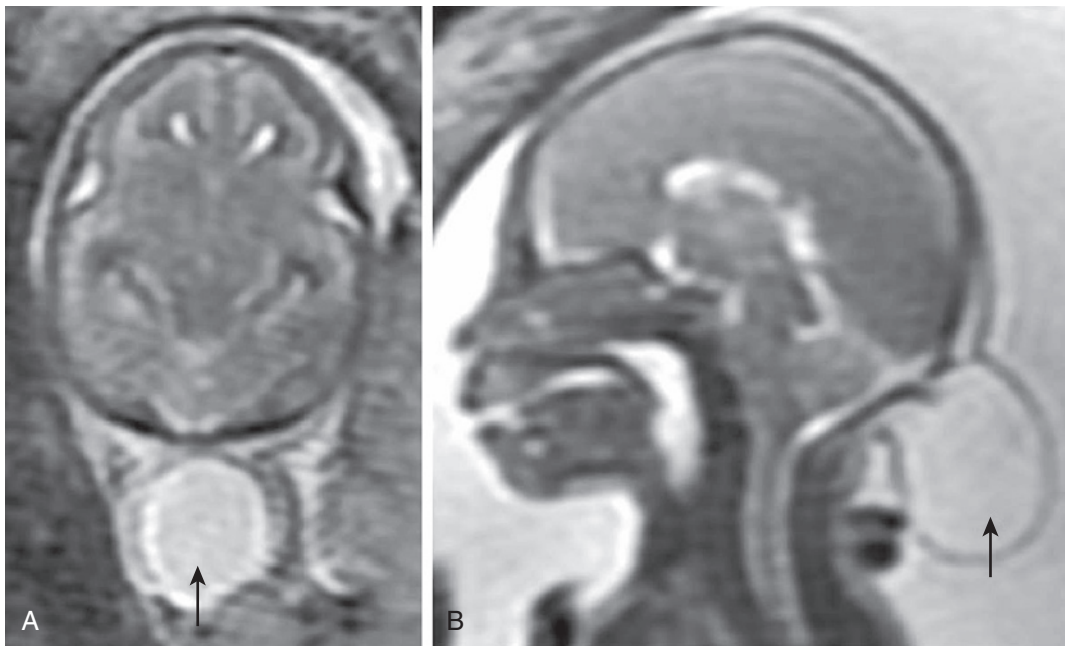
Fetal magnetic resonance imaging (MRI) showing occipital meningocele. T2-weighted fetal MRI axial (A) and sagittal (B) views showing cerebrospinal fluid-filled cystic lesion (arrows) apparently devoid of brain parenchymal tissue.
